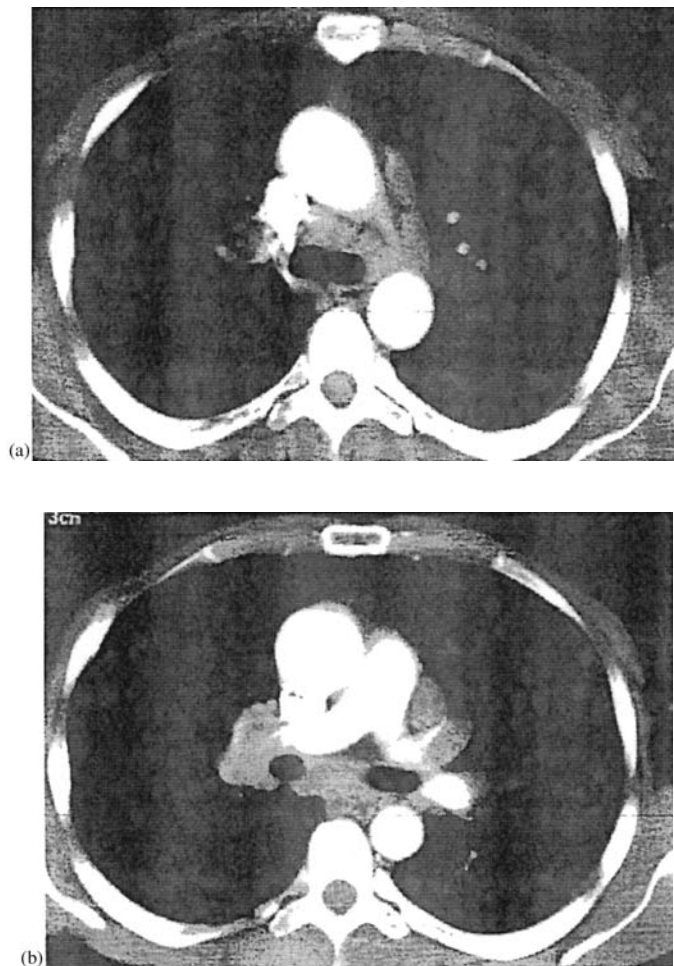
(a) Sarcoidosis. Conventional CT scan at the level of the aortic arch demonstrates pre-tracheal and para-aortic lymph node enlargement. (b) Sarcoidosis. Conventional CT scan from the same patient at the level of the carina demonstrates bilateral hilar lymphadenopathy, marked widening of the carina, and subcarinal lymph node enlargement.
